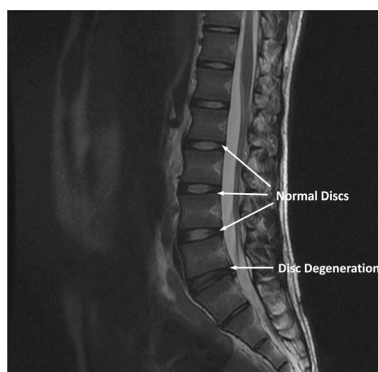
Mid-sagittal lumbar MR image showing degenerative and non-degenerative discs
